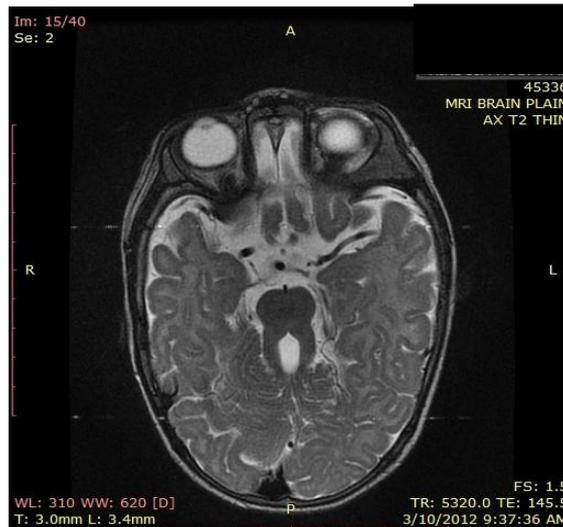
MRI of the patient with Joubert's syndrome
